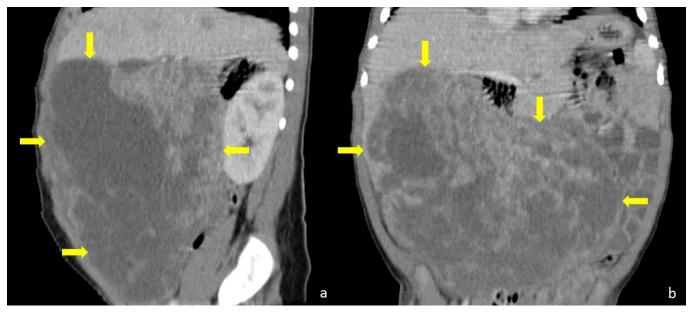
Two year old boy with mesenchymal hamartoma of the liver. Contrast enhanced low dose CT, performed with a GE Light Speed Plus (4 slice-CT). Injection of 28ml (2ml/Kg) of 300mg/ml iodine concentration non-ionic contrast agent. Sagittal (a) and coronal (b) reconstructions of 2,5mm thickness, demonstrate a large intra-peritoneal mass (arrows) measuring 16x9x15cm. It displaces the bowel loops to the periphery. The mass is heterogeneous, containing multiple areas of water density with no contrast-enhancement, corresponding to the cystic components of the lesion.
